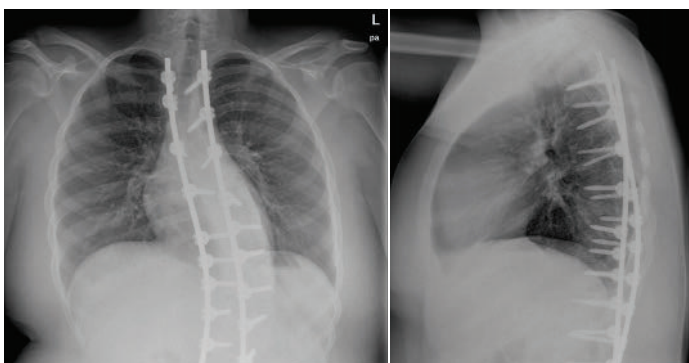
Anteroposterior (a) and lateral (b) x-ray views of segmental fixation in the thoracic spine. *Image source:* chestdevices.com.
